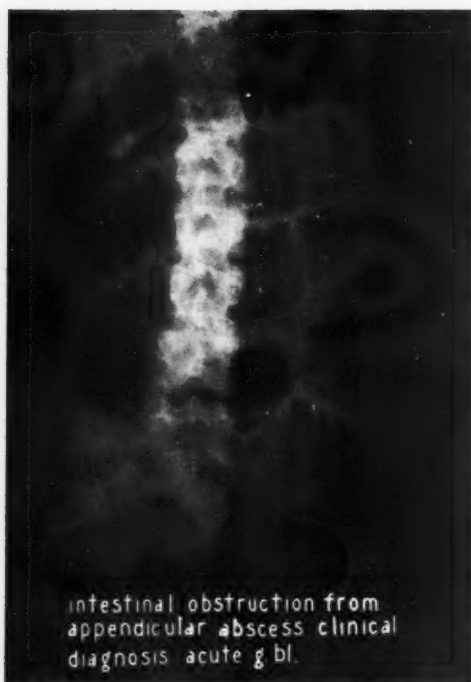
Clinical diagnosis was acute cholecystitis but roentgenograms demonstrated intestinal obstruction. The patient complained of diffuse abdominal pain, with vomiting; pain in epigastrium (no relation to meals); abdomen moderately distended.
